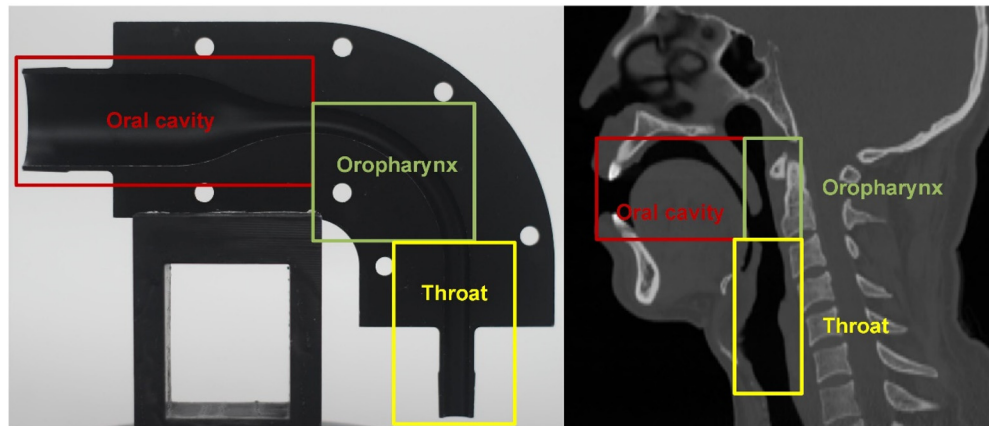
Idealized MT model and human CT image with labeled oral cavity, oropharynx, and throat.
